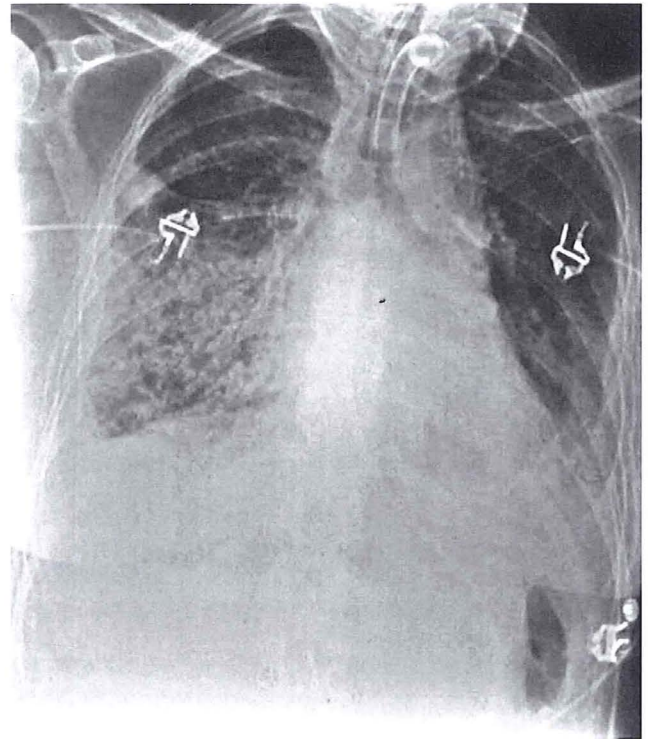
Postoperative chest X-ray of patient 1 who developed respiratory insufficiency due to infiltration of the right lower lobe and chylous bronchorrhoe after successful video-assisted thoracic duct ligation.
